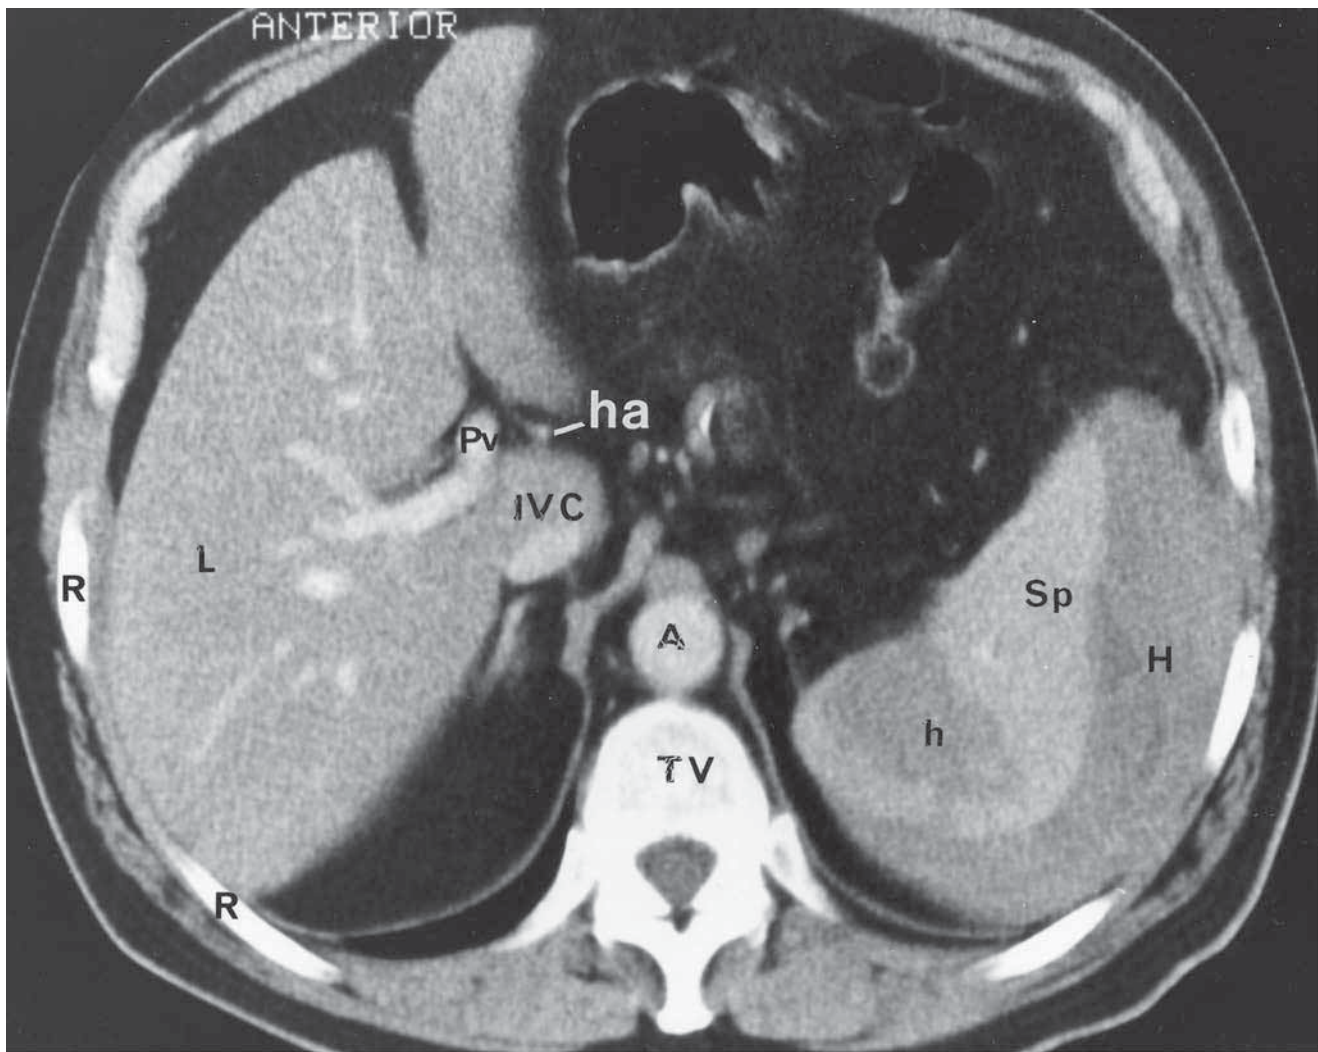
CT through the Upper Abdomen
